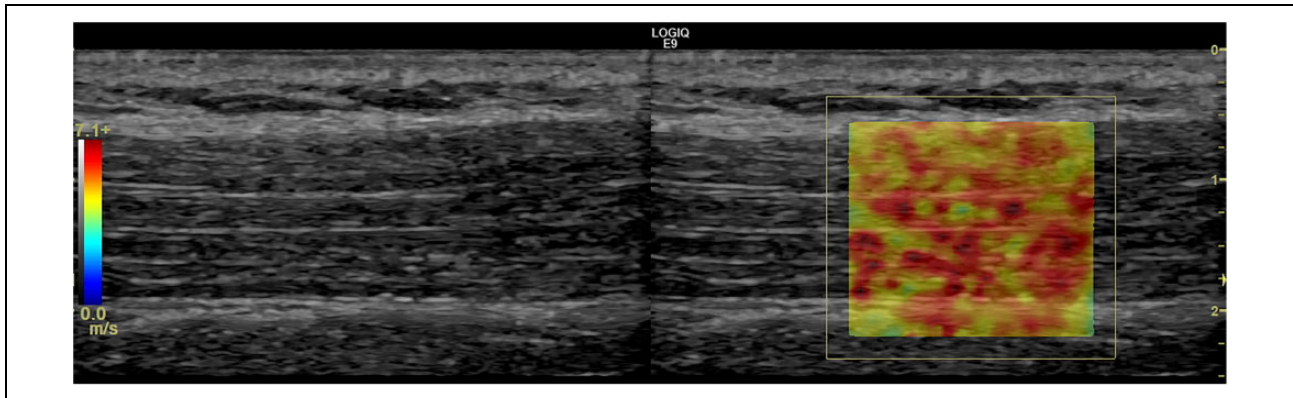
B-mode ultrasound images of the lateral part of the right upper trapezius muscle in a healthy subject (left) with the SWE image overlaid (right). The color scale on the left shows the corresponding speed of the shear waves. SWE: shear wave elastography.
